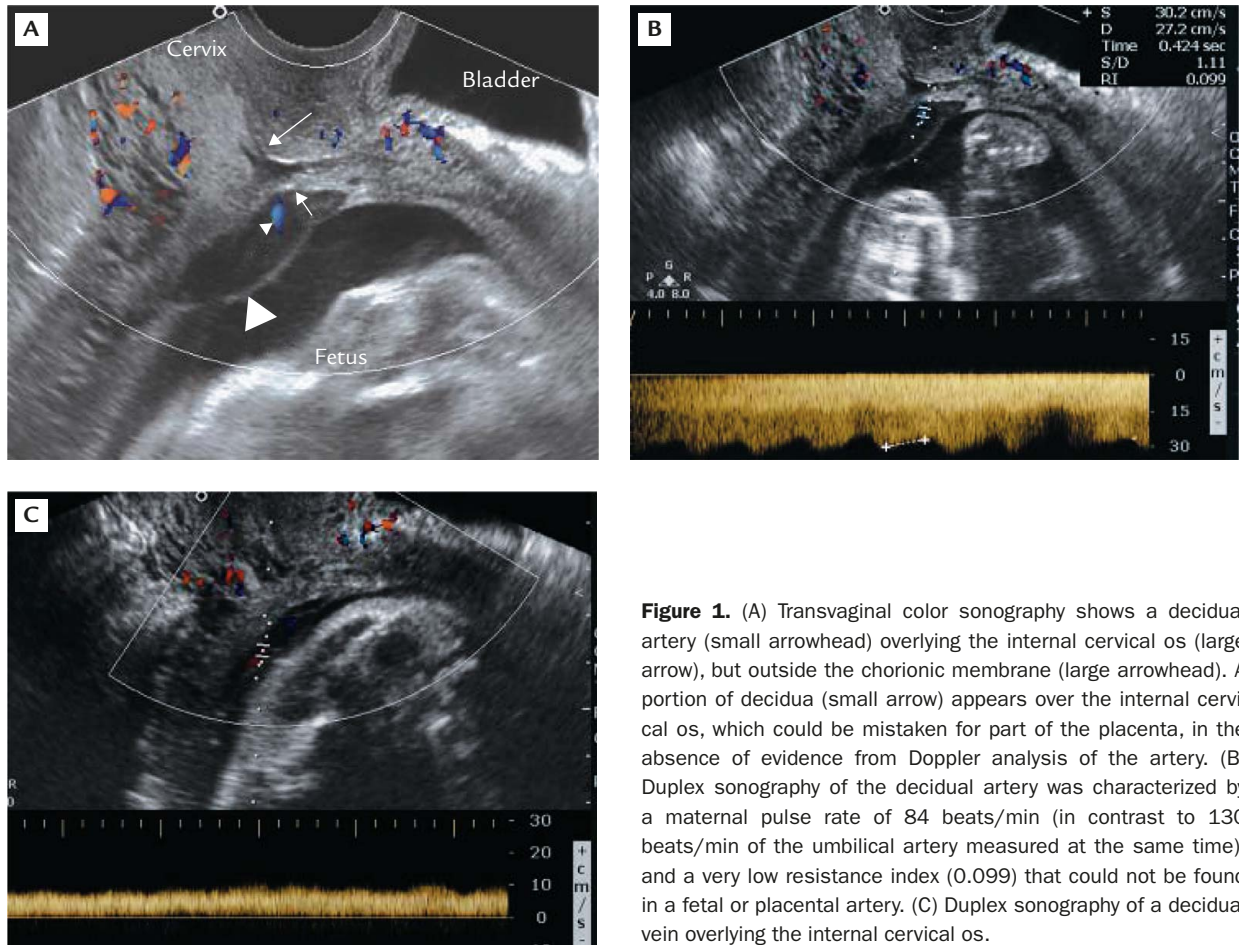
(A) Transvaginal color sonography shows a decidual artery (small arrowhead) overlying the internal cervical os (large arrow), but outside the chorionic membrane (large arrowhead). A portion of decidua (small arrow) appears over the internal cervical os, which could be mistaken for part of the placenta, in the absence of evidence from Doppler analysis of the artery. (B) Duplex sonography of the decidual artery was characterized by a maternal pulse rate of 84 beats/min (in contrast to 130 beats/min of the umbilical artery measured at the same time), and a very low resistance index (0.099) that could not be found in a fetal or placental artery. (C) Duplex sonography of a decidual vein overlying the internal cervical os.
